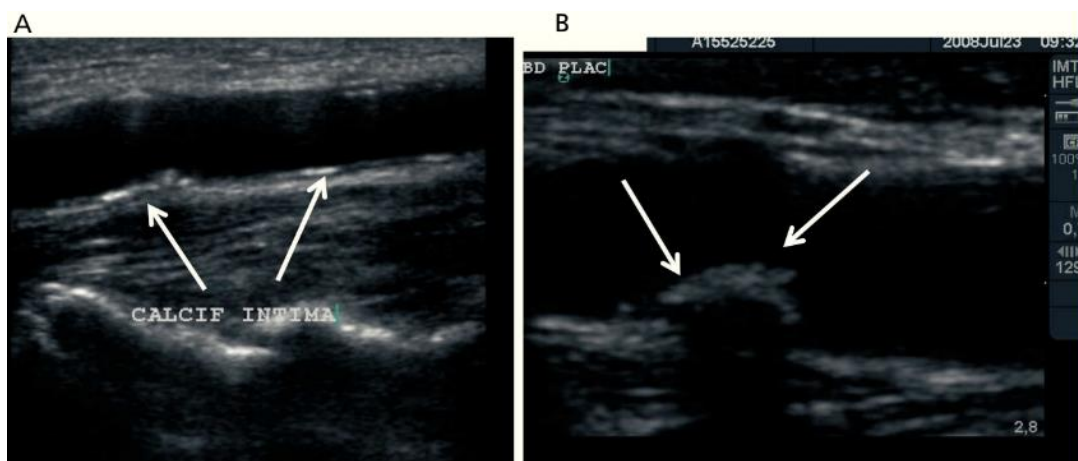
Calcification patterns portrayed by ultrasound* (Betriu-Bars and Fernández-Giráldez, 2012). A: Linear calcification in the CIMT. B: Calcified plaque with posterior acoustic shadowing.
